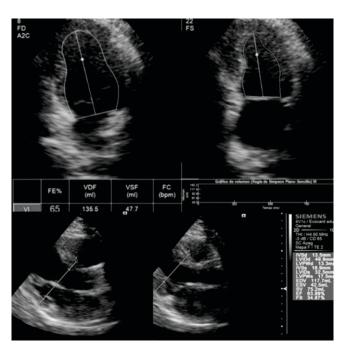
Echocardiogram one year after treatment. Preserved LVEF and decreased left ventricular volume are seen.
